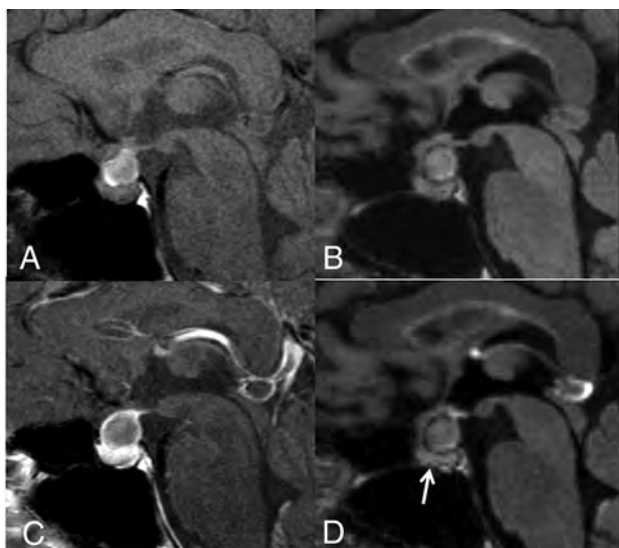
A 40-year-old woman with an RCC. On the postcontrast T1WI (C) compared with the precontrast T1WI (A), the cyst wall is enhanced (grade 2), as is the pituitary gland. Unlike the precontrast 3D T2-FLAIR image (B), the postcontrast image (D) shows no contrast enhancement (grade 0). Different from the postcontrast T1WI (C), the pituitary gland is not enhanced on the postcontrast 3D T2-FLAIR image (arrow in D). The observer judged this lesion as equivocal (scale 3) at the conventional MR interpretation, whereas the confidence level was changed to probably an RCC (scale 2) by the addition of 3D T2-FLAIR interpretation.
